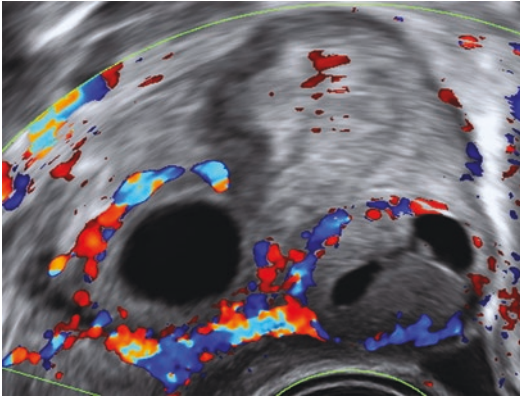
Color Doppler facilitating the differentiation between the corpus luteum and an ovarian ectopic
